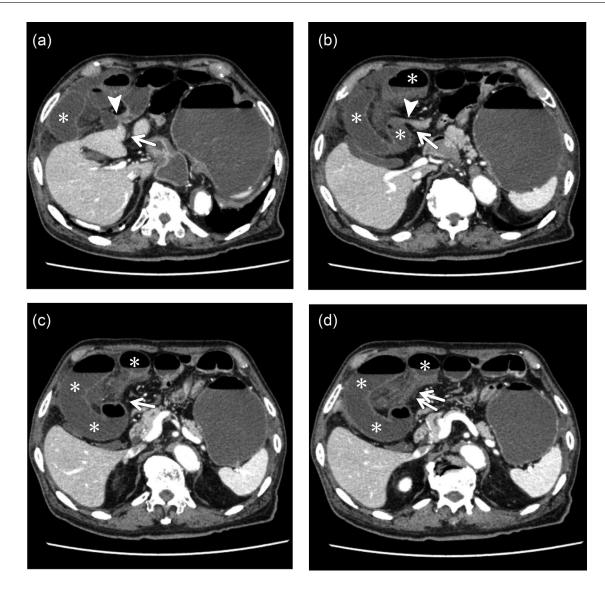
Contrast-enhanced CT. Cranial (A) to caudal (D) axial CT images show a double beak sign (arrowhead) in front of the medial segment of the liver; the closed-loop small bowel (asterisk) is seen in the right side of the round ligament (arrow).
